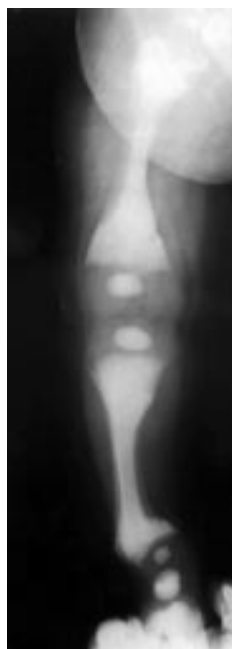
Plain radiograph of right lower limb showing generalised osteosclerosis and a "bone within a bone" appearance. The metaphyses are irregular and there is varus deformity of the distal tibia and proximal femur. These are characteristic appearances of osteopetrosis and secondary rickets.
